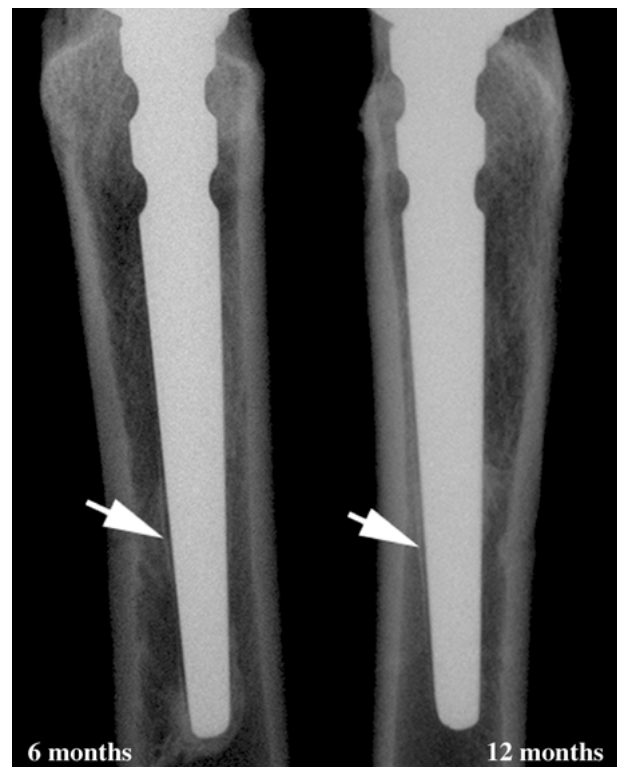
Post-mortem radiographs (lateral view) of the sandwich-coated implant after 6 and 12 months of implantation. Arrows indicate the presence of a translucent line around the distal uncoated part of the stem.
